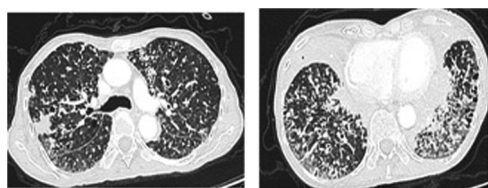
Chest CT scan: Multiple nodules with soft tissue density, with random distribution in both lung fields, diameters between 2–14 mm, and tendency to consolidation.
